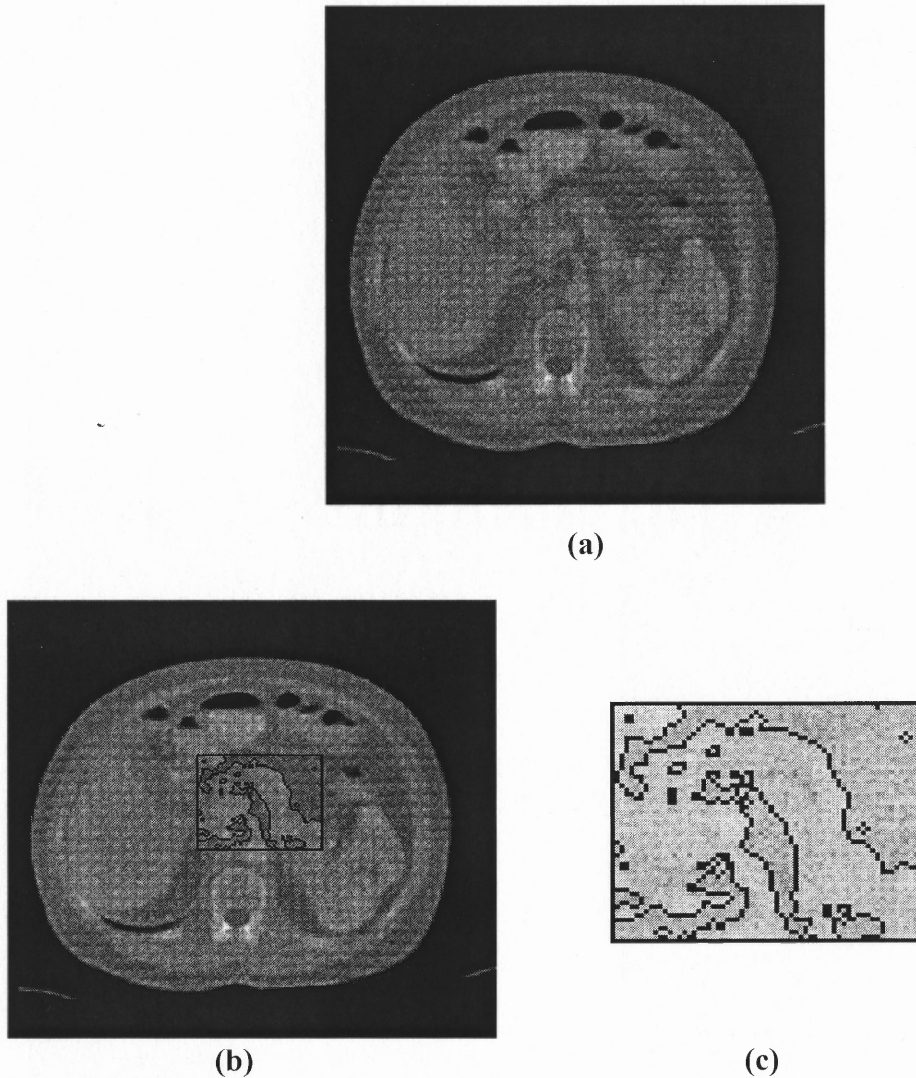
An axial CT slice of the abdomen, (a) Pancreas segmented using 2 clusters. (b) Enlarged view of the segmented pancreas.
